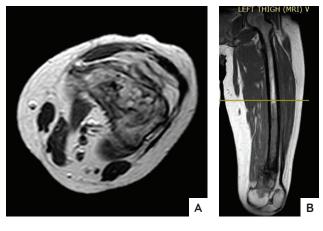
MRI after neoadjuvant chemotherapy. Axial cuts show no contamination of the knee joint (A). Extensive intramedullary involvement proximally (B).
